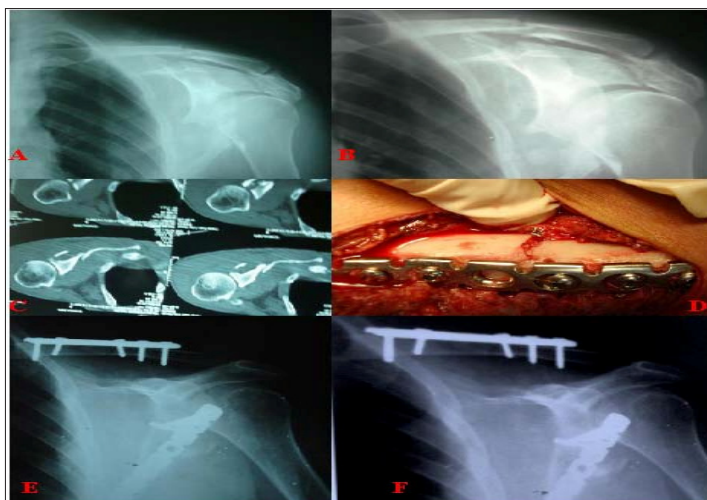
Male Patient 42 Years Old With Floating Shoulder Injury: A&B) Preoperative X-Ray Showing Fracture Clavicle with Displaced Fracture Scapula; C) C-T Scan for the Scapular Fracture with Displacement; D) Intraoperative Photo with Plate Fixation; E) Immediate Postoperative X-Ray Showing Internal Fixation of Clavicle And Scapula ; F) X-Ray 1 Year Postoperative With United Both Fractures in Good Position.
